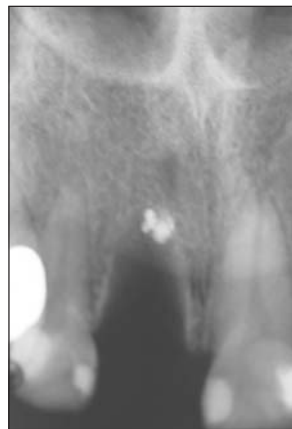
After the third surgery failed, the tooth was extracted. Remnants of the retrograde root filling can be observed on the radiograph.
